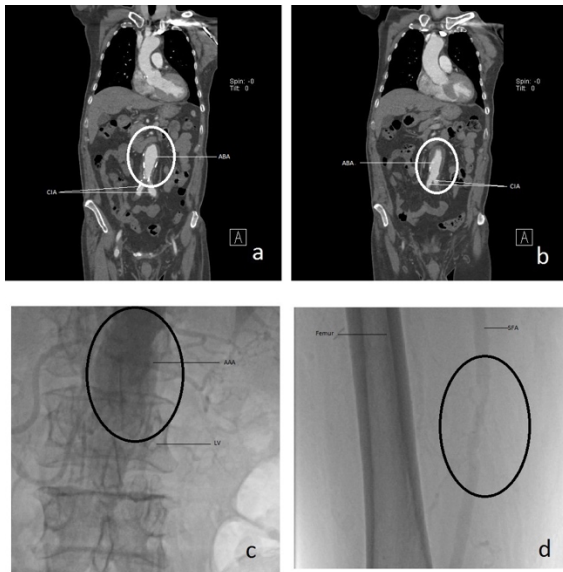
Aneurysmatic dilatation and atherosclerotic calcification detected on CT(a-b), and conventional angiography (c), 70-80% peripheral lesion detected on conventional angiography (d). (ABA: Abdominal aorta, CIA: Common iliac artery, SFA: superficial femoral artery, LV: lumbar vertebra)
